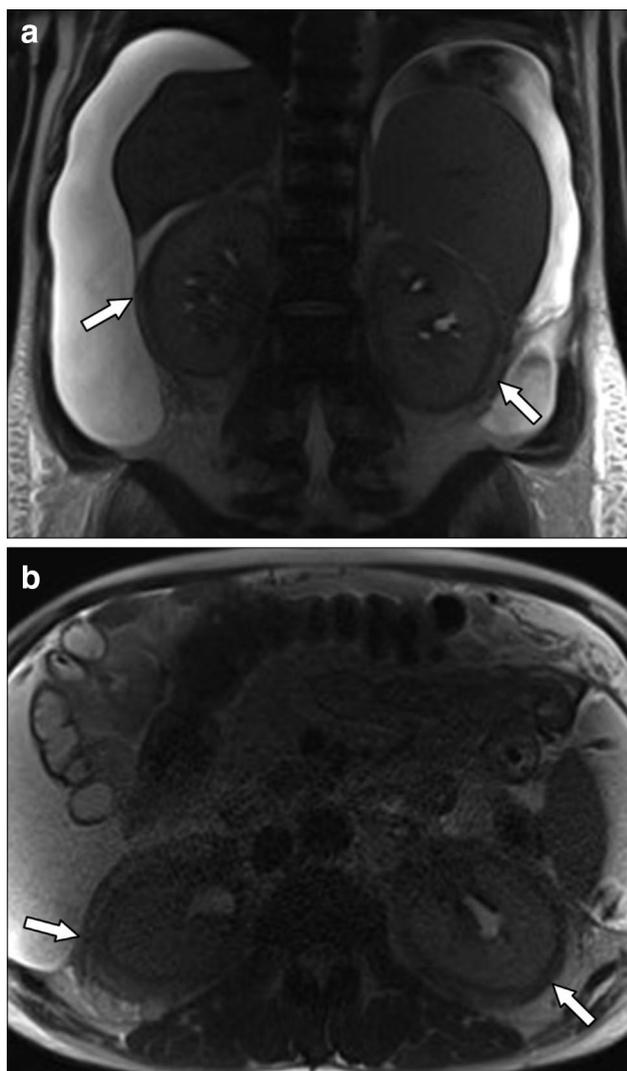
51-year-old with Erdheim–Chester Disease. a, b Axial and coronal T2-weighted images demonstrate confluent T2-hypointense tissue encasing the bilateral kidneys (arrows). There is extensive abdominal and pelvic ascites due to liver dysfunction as part of Erdheim–Chester disease. Case courtesy of Erick Remer, MD, Cleveland Clinic
